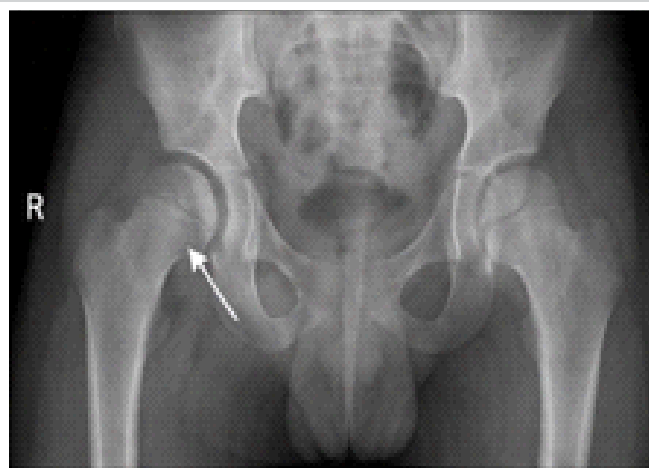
Pre-operative radiograph (anteroposterior pelvis) of a 7-year-old boy with right hip septic arthritis showing widening of the hip joint space and hazy articular contours (arrow).
